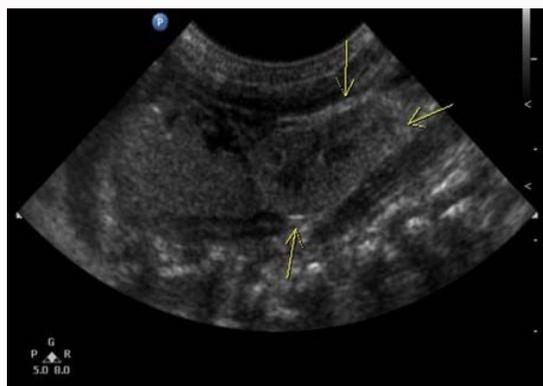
Kidney sonography at birth. (Right kidney is not visible. Hypoplastic left kidney whose size is 2.09 cm and a rotational variation in the left renal fossa with poor corticomedullary differentiation).
